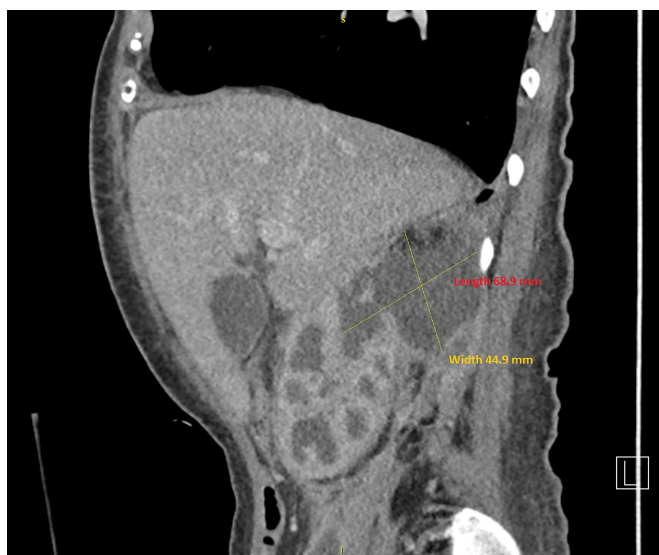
CT Urogram. CT urogram demonstrating calyceal rupture of the upper pole of the right kidney with formation of a urinoma, that begins posterior to the kidney and tracks through the retroperitoneum.
